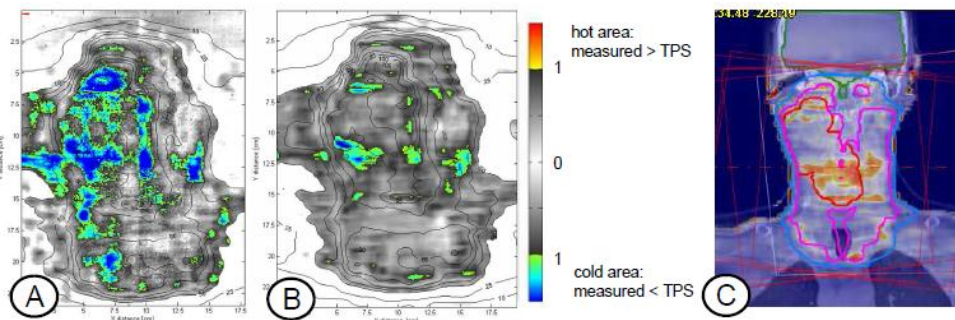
Mean gamma evaluations of (A) TPS vs film (B) TPS vs COMPASS plane QA (C) TPS vs COMPASS CT QA
